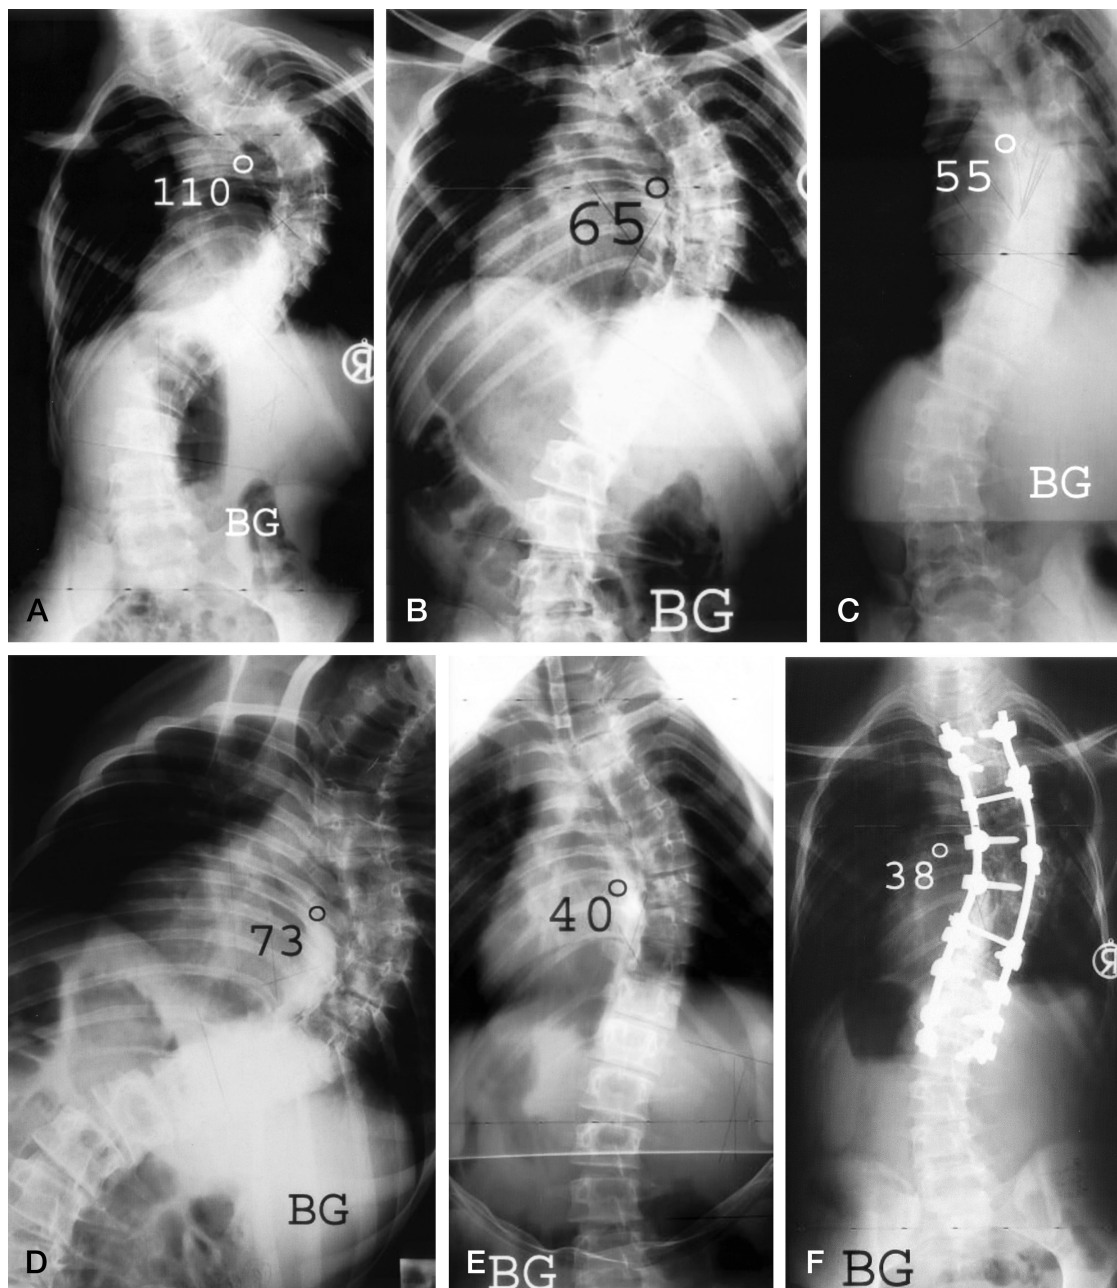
A, Standing anteroposterior radiograph of a patient with 110° severe thoracic curve. B, Curve is decreased to 65° in supine traction radiograph. C, Fulcrum radiograph shows correction of the curve to 55°. D, Curve is quite rigid and decreased to 73° on maximal lateral bending, which made us think that anterior release should be performed as an initial procedure. E, Traction with the patient UGA just before surgery showed much better flexibility, which made us proceed with posterior surgery. F, Only posterior surgery using segmental pedicle screws provided even more correction.
